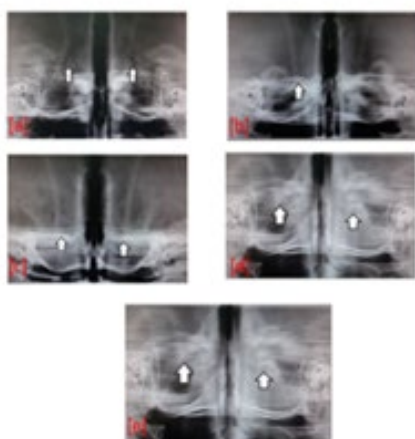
Frederic Rating Scale [A] Score 0-Open Suture; [B] Score 1-Shows Less Than 50 Percentage Of Lambdoid Suture Closed; [C] Score 2-Shows More Than 50 Percentage Of Lambdoid Suture Closed; [D] Score 3-Shows Most Of The Part Of Lambdoid Suture Closure; [E] Score 4-Shows Total Closure With No Visible Suture Line (RPRg Radiograph Taken From The Present Study).
